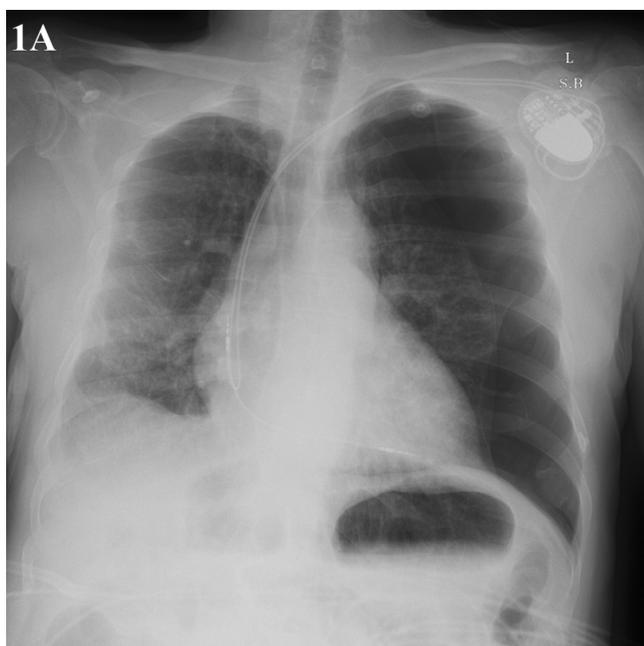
Chest X-ray acquired 24 hour after placement of dual chamber pacemaker showing left-sided pneumothorax (arrow) with a shift of the mediastinum to the right side of the thorax.
